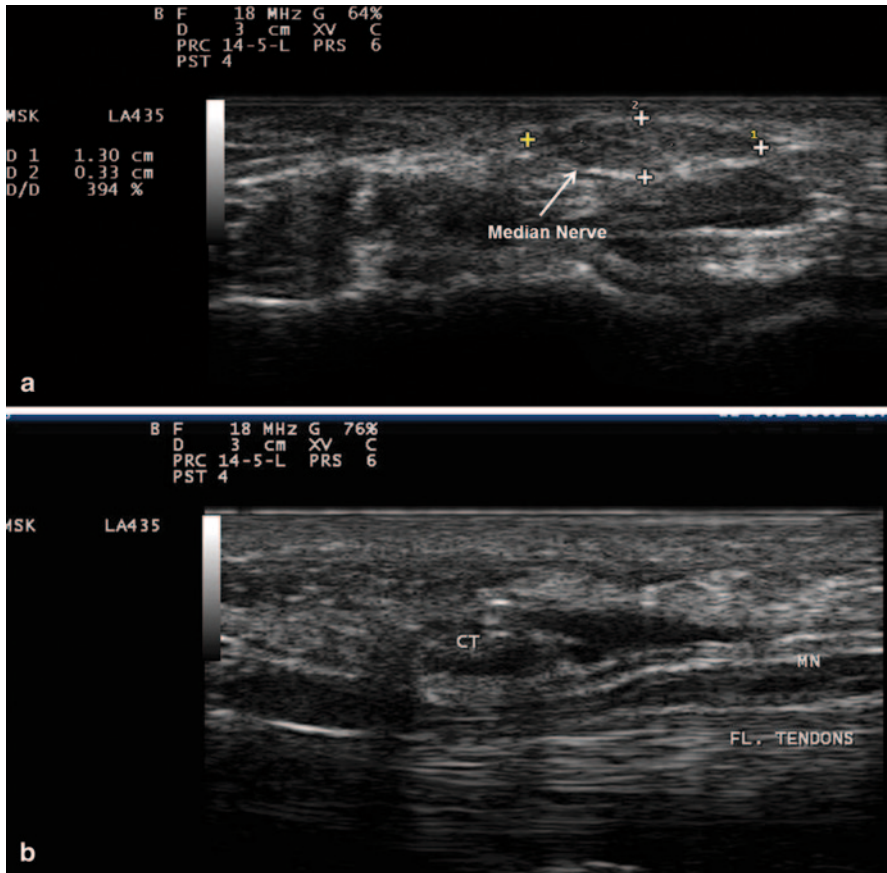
Gray scale US using Esaote Mylab 25 system: Palmar view at the proximal inlet of the carpal tunnel showing: a Transverse view of the median nerve swelling manifested by increased median nerve cross-section area in a subject with carpal tunnel syndrome. b Longitudinal view showing compression of the median nerve at the proximal inlet of the carpal tunnel whereas there is increased nerve width at both tunnel inlet and outlet. *MN* median nerve, *Fl. Tendons* flexor tendons, *CT* Carpal Tunnel
